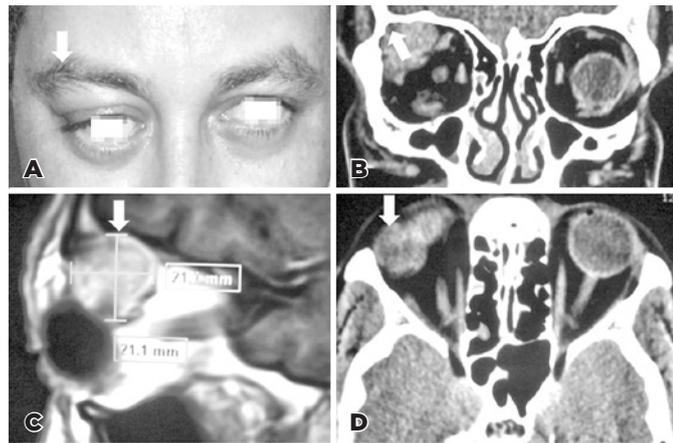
Pleomorphic adenoma of the lacrimal gland. (A) Patient with right-sided proptosis (arrow). (B) Coronal computed tomography (CT) evidencing the erosion of the orbital roof (arrow). (C) Sagittal magnetic resonance imaging (MRI) shows tumor size (arrow). (D) Axial CT presents a large enhancing mass with irregular borders of the right lacrimal gland (arrow).
